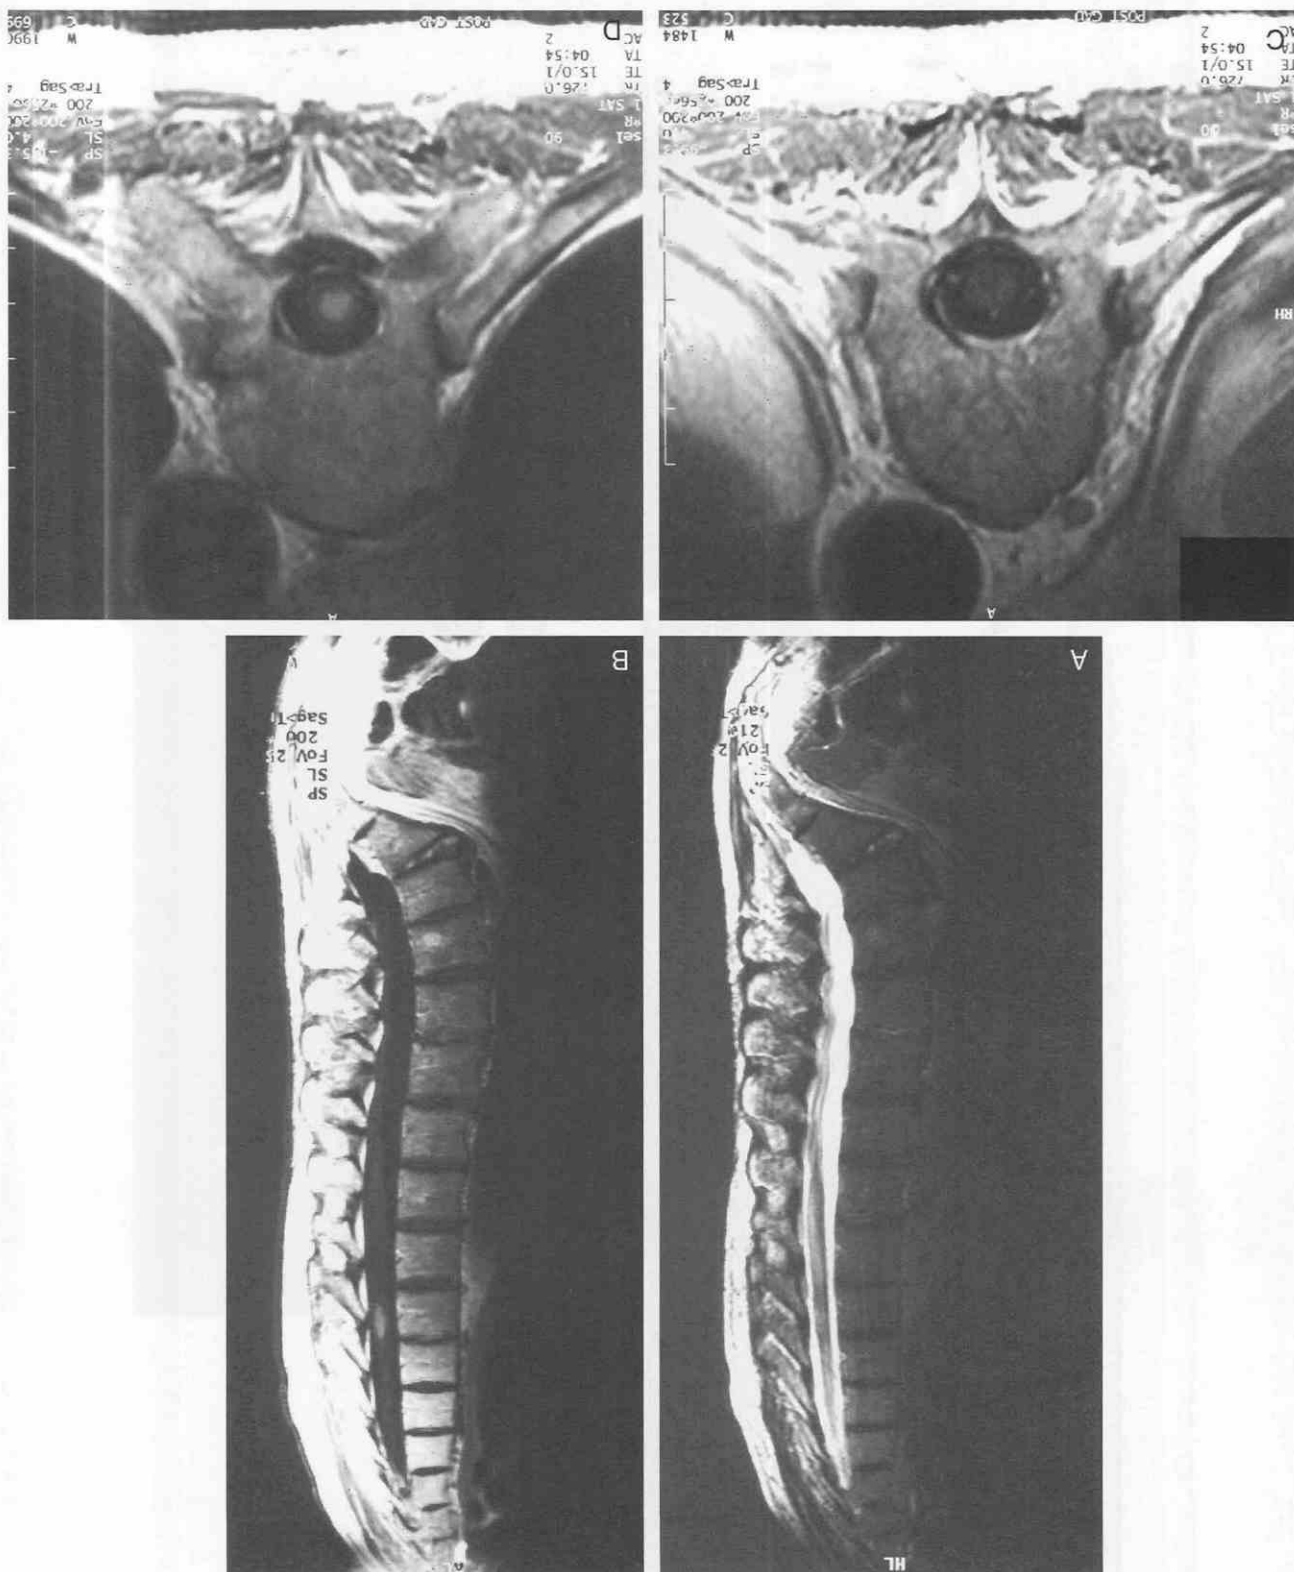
Hematogenous metastasis to the conus medullaris from lung carcinoma. *A*, T1-weighted sagittal MR image shows expansion of the inferior cord. *B*, T2-weighted sagittal MR image demonstrates abnormal hyperintense signal in the conus and a more focal area of greater signal intensity. *C*, Postcontrast T1-weighted sagittal MR image shows heterogeneous enhancement extending over the length of more than one vertebral body of the lower cord. *D*, A gradient-echo, FLASH (fast low-angle shot), T2-weighted axial section confirms cord expansion and the central signal intensity abnormality. *E*, Postcontrast T1-weighted axial section highlights a focal area of greater enhancement.
